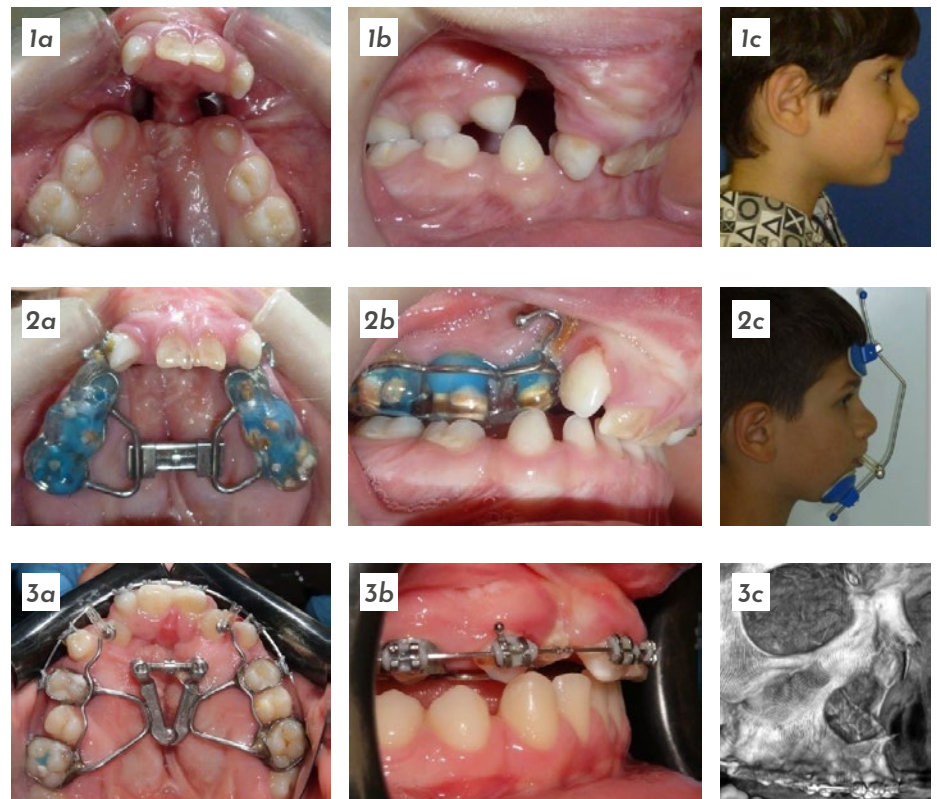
Representative case of a patient with bilateral complete cleft lip and palate (BCLP) presenting with large alveolar gaps at baseline. He was offered in the centre where he had had primary surgery a premaxillary set-back and bone grafting, followed by maxillary distraction. (1a-c) Occlusal and lateral view at T0 showing wide bilateral alveolar clefts with deficient soft tissues, and lateral extraoral view of the patient. (2a-c) After RPE expansion and orthopaedic protraction with protraction face mask: occlusal and lateral views showing significant reduction of cleft width and improved soft-tissue conditions at T1. (3a-b) Occlusal and lateral views 7 years after secondary alveolar bone grafting (T2); (3c) CBCT scan confirming long term successful bone fill of the grafted area.
